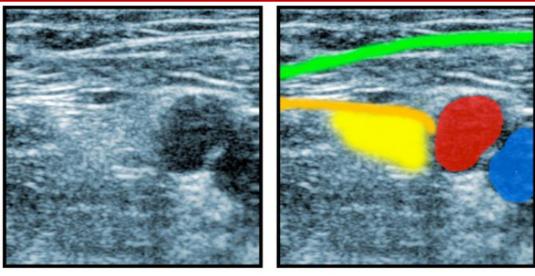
Ultrasound image of femoral artery (red), femoral vein (blue), femoral nerve compartment (yellow), fascia lata (green), fascia iliaca (orange)
